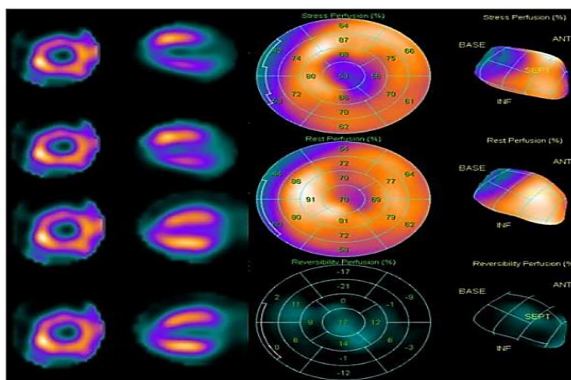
SPECT Images Show Partial Reversible Apical Perfusion Defects, Confirmed on Polar Maps with the 16-Segment Model.
